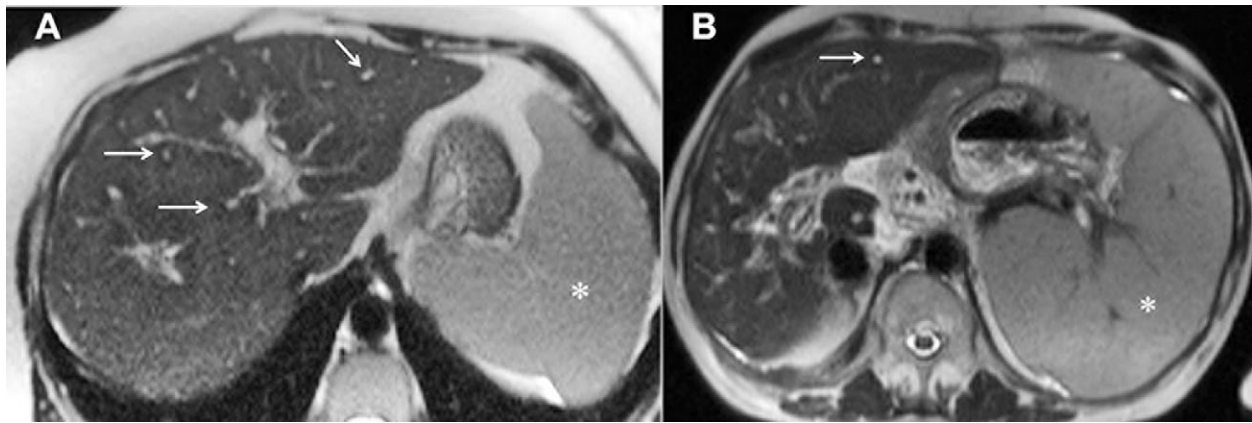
Periportal halo sign in primary biliary cirrhosis. Axial T2-weighted image shows periportal halo sign as hypointense areas around portal veins (arrows) in a 63-year old woman at cirrhosis stage (A). Periportal halo sign (arrow) in a 58-year old PBC patient (B). Note also splenomegaly (asterisk) (A, B).
